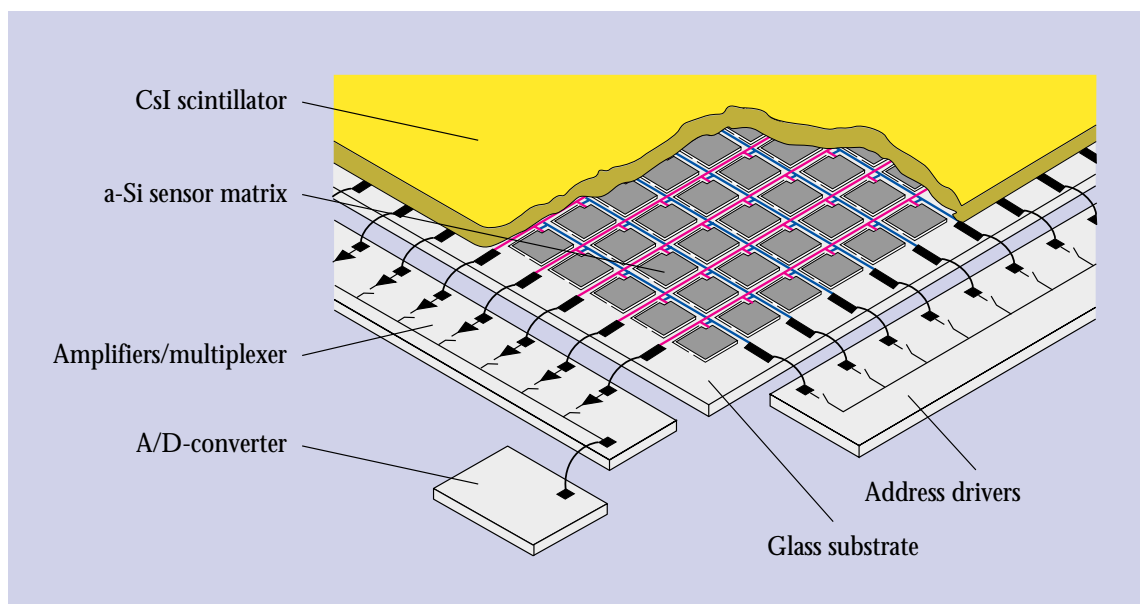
Construction of the flat-panel detector. The X-ray sensitive convertor layer consists of caesium iodide (CsI). The amorphous silicon sensor array comprises 3000 x 3000 pixels.
